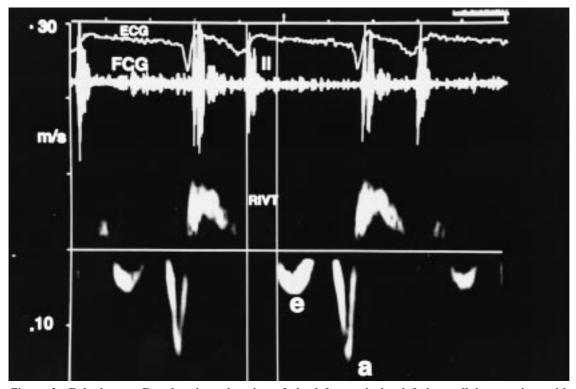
Pulsed wave Doppler tissue imaging of the left ventricular inferior wall in a patient with abnormal regional diastolic function. The sample volume is located in the basal segment of the inferior wall. The pulsed wave Doppler tissue imaging e diastolic wave is decreased and there is an increase of the a wave; the local isovolumetric relaxation time is enlarged.
